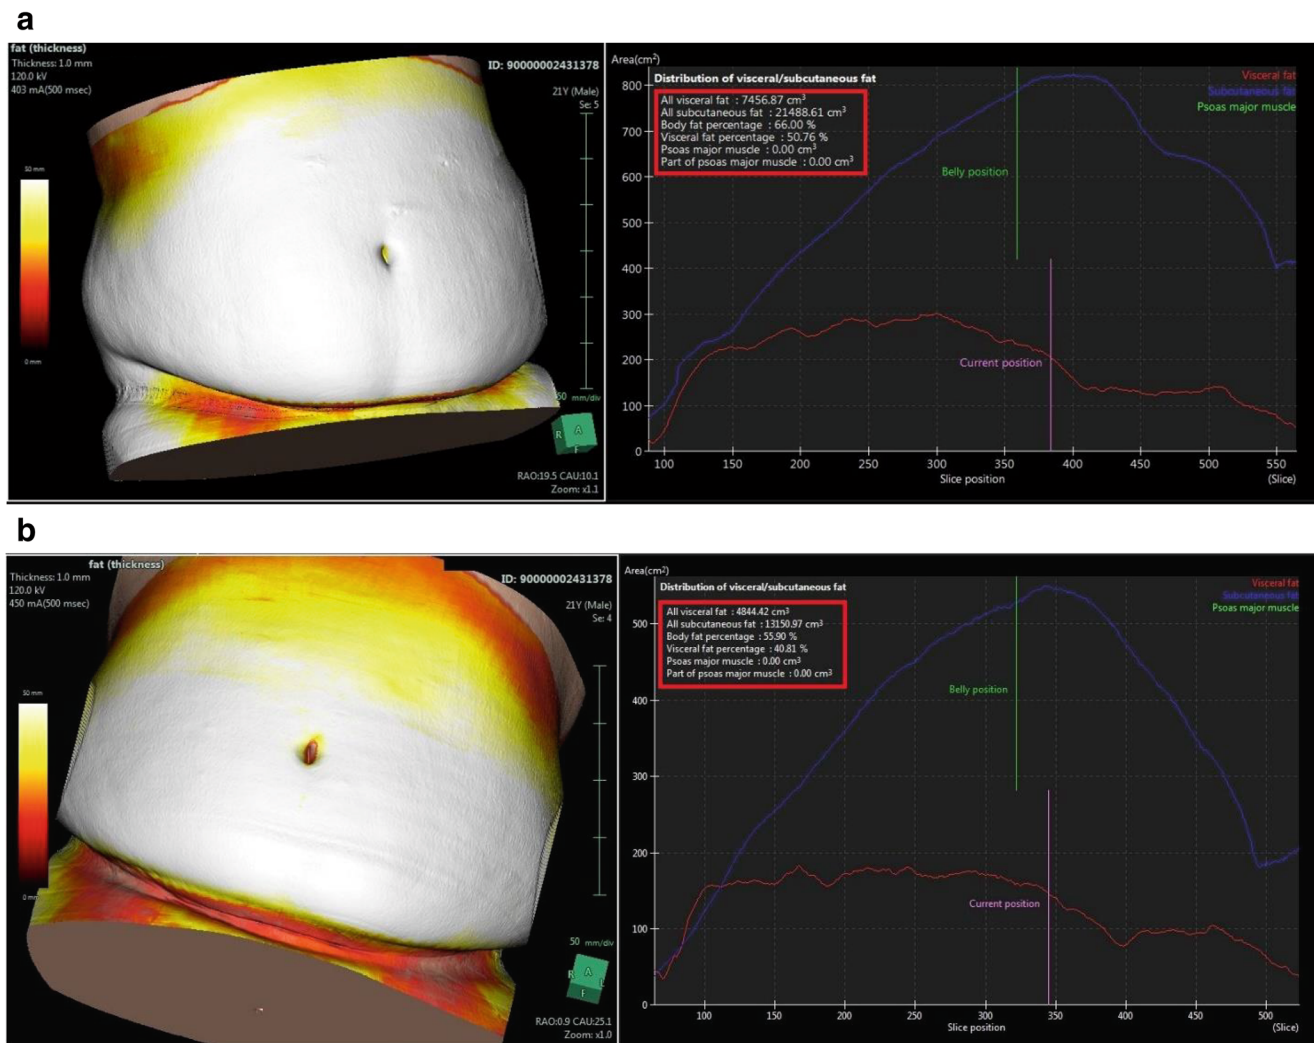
Abdominal CT (3D) in a LSG patient: (a) before operation; (b) 6 months after operation. Subcutaneous (blue) and visceral (red) fat volumes (cm³) are represented in the box with red borders at the right half
